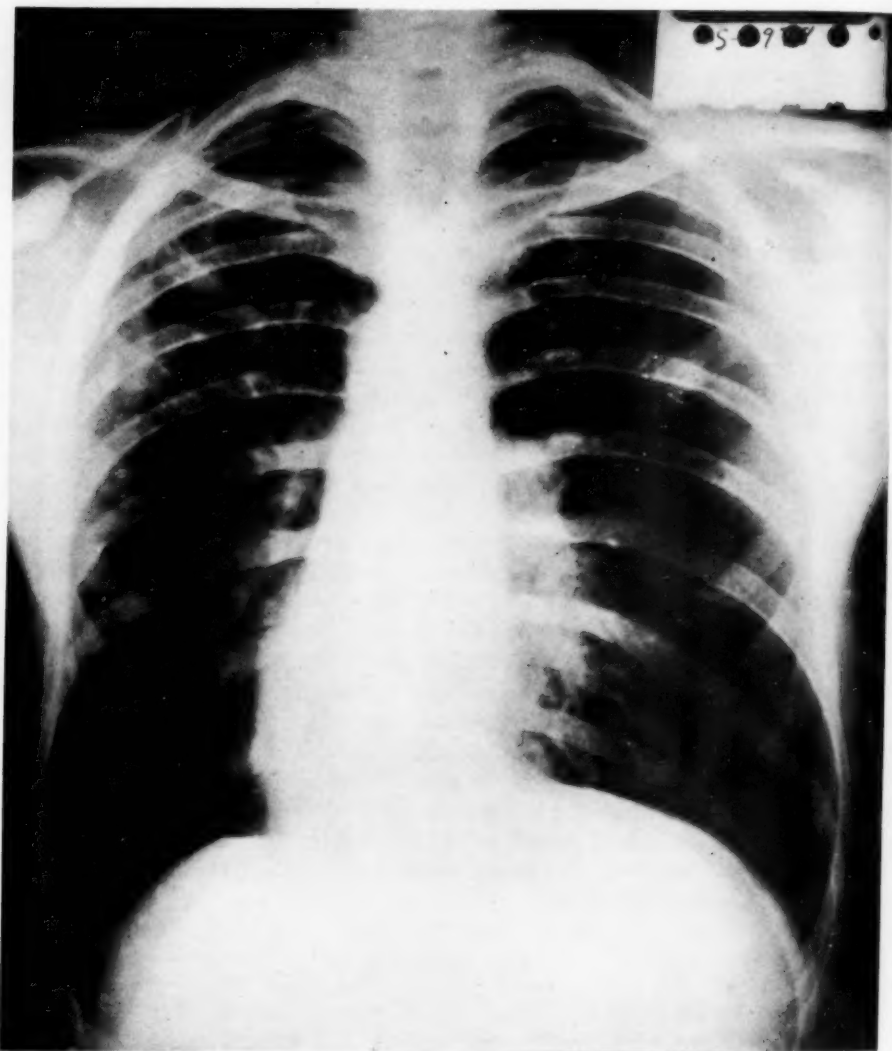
Roentgenogram of chest, May 20, 1930.
